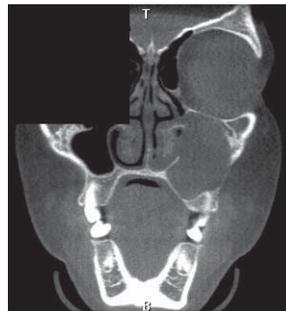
Coronal CBCT view showing involvement of the entire left maxillary sinus.
